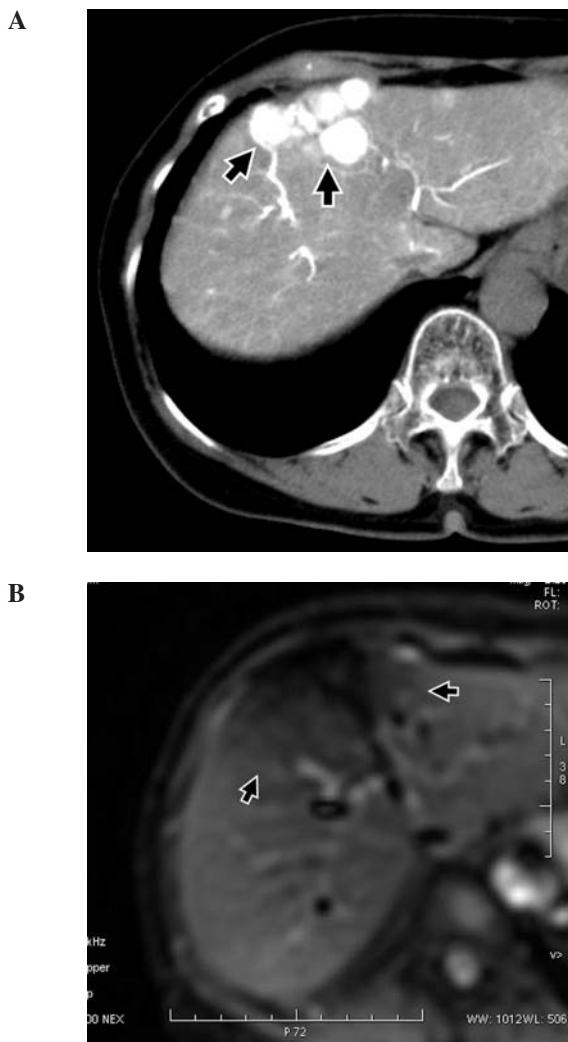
A 78-year-old woman with multiple HCCs in the left medial segment of the liver. (A) Contrast-enhanced CT through the intra-arterial catheter depicting multiple HCCs (arrow). (B) DWI before TACE with degraded quality due to artifact, resulting in missed tumors (arrow).
